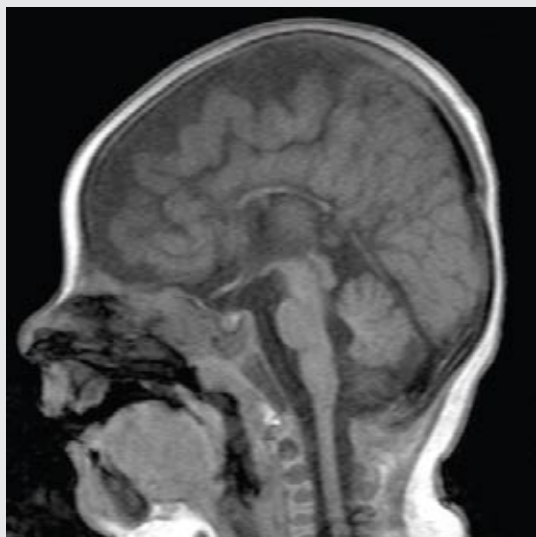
Magnetic resonance imaging scan: Sag T1W SE, midline. There is hypoplasia of the corpus callosum. Optic chiasm, pituitary gland and midbrain are grossly normal.
